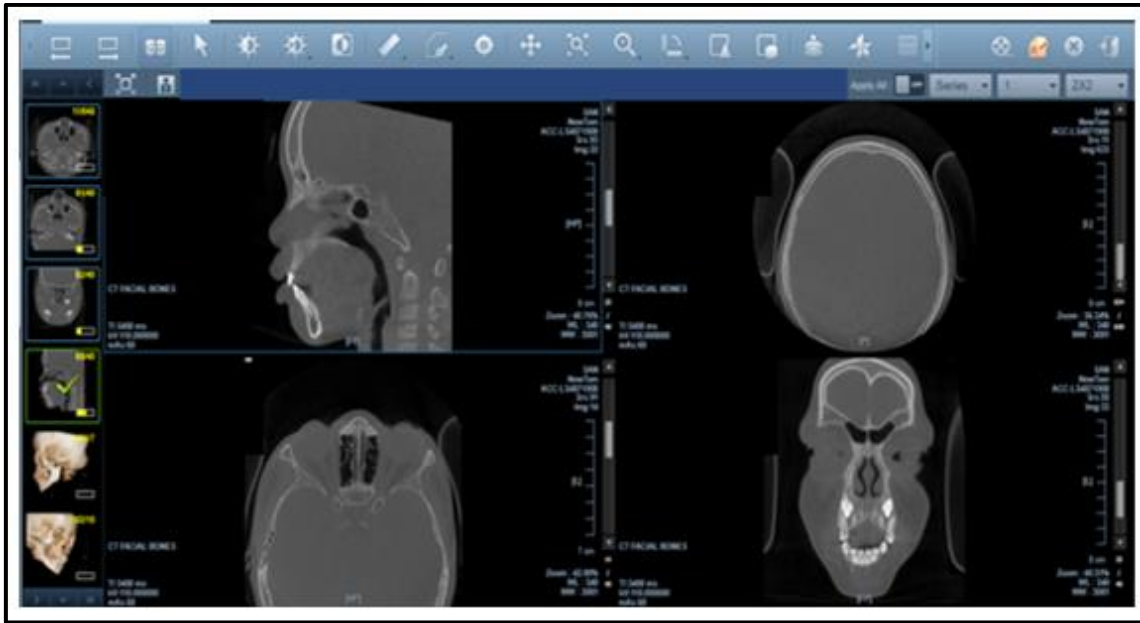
Image of the Infinitt software (version 5.0.1.1) used to analyse CT scans
